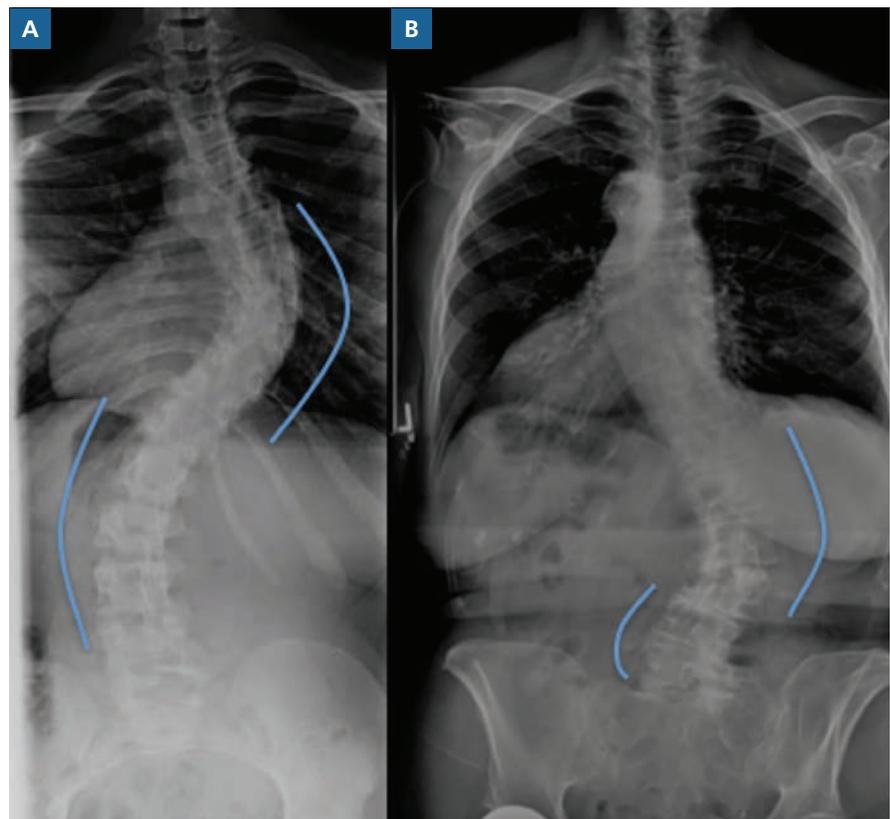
Radiographic comparison of A, adult idiopathic scoliosis (IS) and B, adult degenerative scoliosis (DS). In IS, the lumbar curve and compensatory thoracic curve are similar sizes. However, in DS, patients generally present with a lumbar curve without a fixed structural secondary curve. Instead, a compensatory lumbar curve is observed in the lower lumbar spine. Additionally, in IS, a rotatory deformity can be observed in the entire lumbar spine (limited to apex of the curve in DS). A lateral subluxation can also be observed in DS spines.
